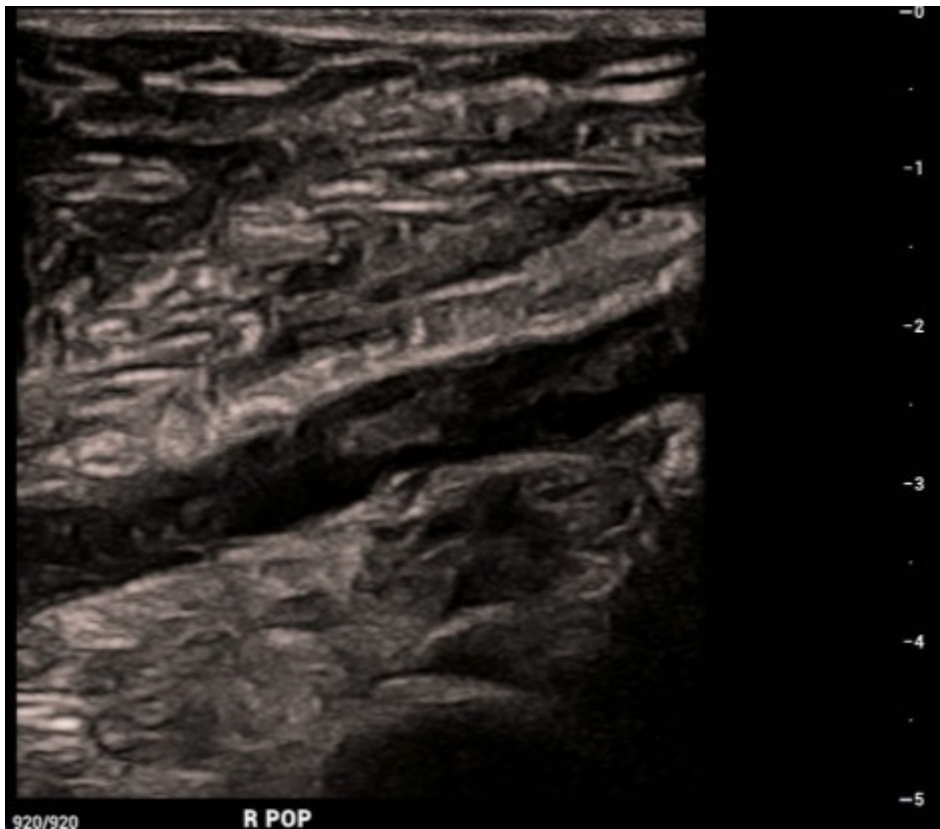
Long-axis grayscale ultrasound image of the popliteal vein with echogenic filling defect in the lumen that is not compressible (compression images not shown).
